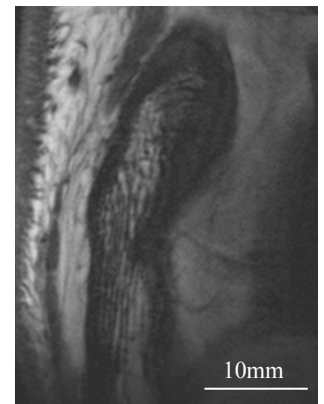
Ultra-high resolution MR image allows visualization of trabecular bone in the maxilla.
